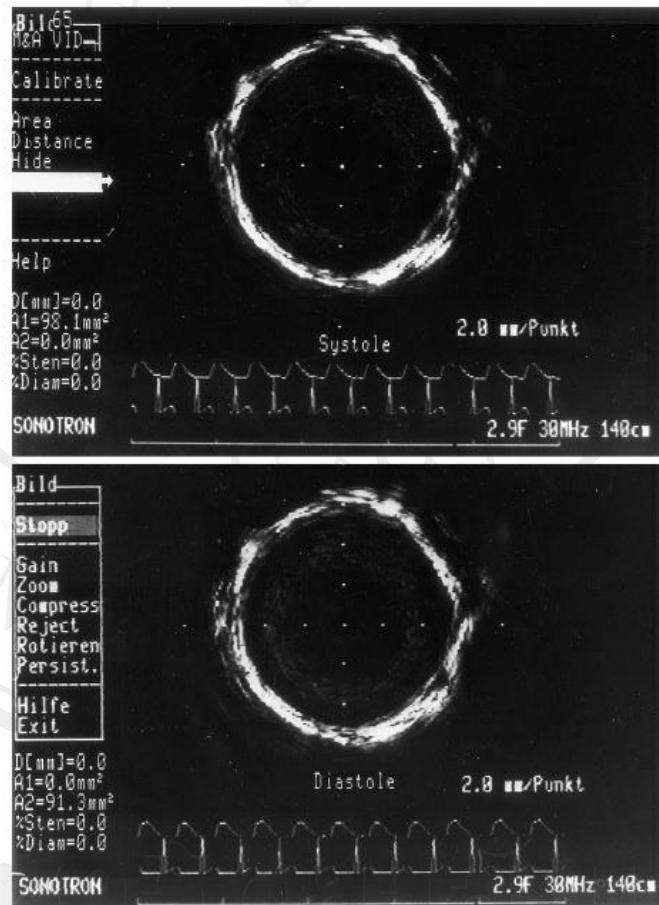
Representative example of systolic (top) and diastolic (bottom) images of abdominal aorta recorded with intravascular ultrasound (IVUS). Boundaries of inner lumen are clearly detectable. (Hardt *et al.*, 1999)
